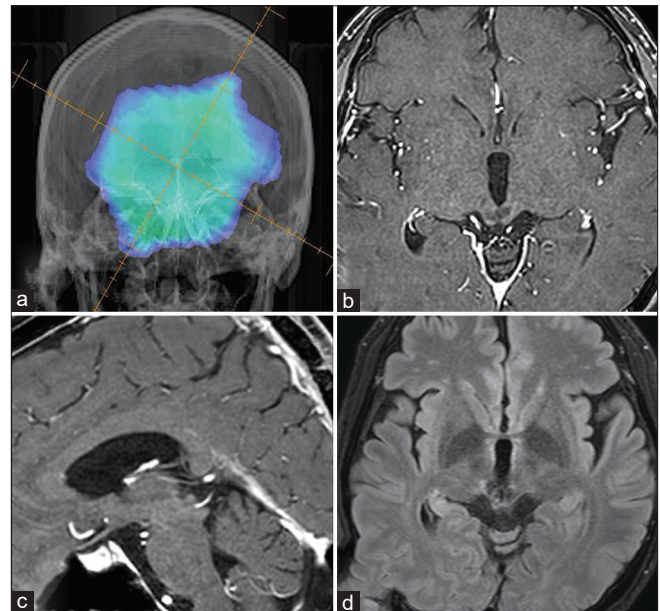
Dose distribution of whole-ventricle irradiation (a). Axial (b) and sagittal (c) views of enhanced T1-weighted following completion of chemoradiation therapy. The enhanced lesion disappears. The FLAIR image after 5 years of treatment reveals no recurrence or late radiation morbidity (d).
